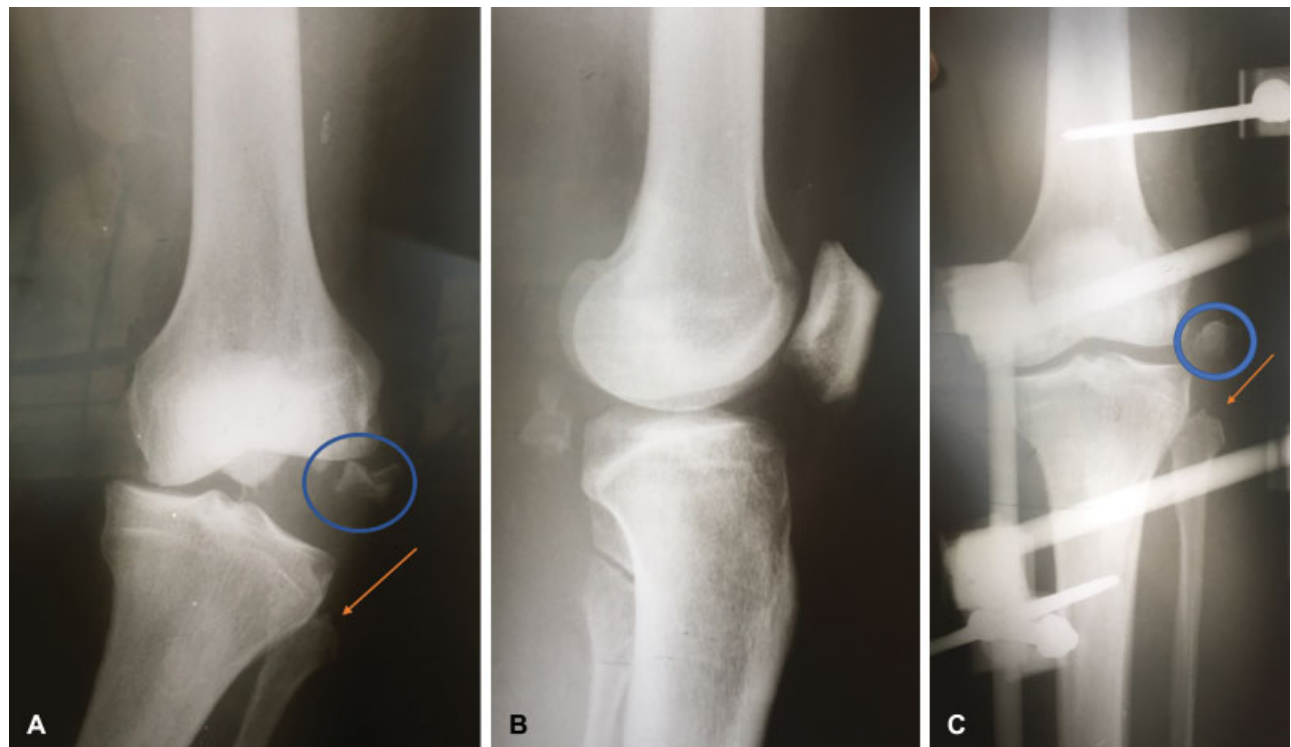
(A) Anteroposterior (AP) radiograph of the opening of the lateral joint space and bone fragment of the anterolateral tibia (circle) and avulsion of the head of the fibula (arrow). (B) Profile radiograph. (C) Radiograph after transarticular external fixation.
